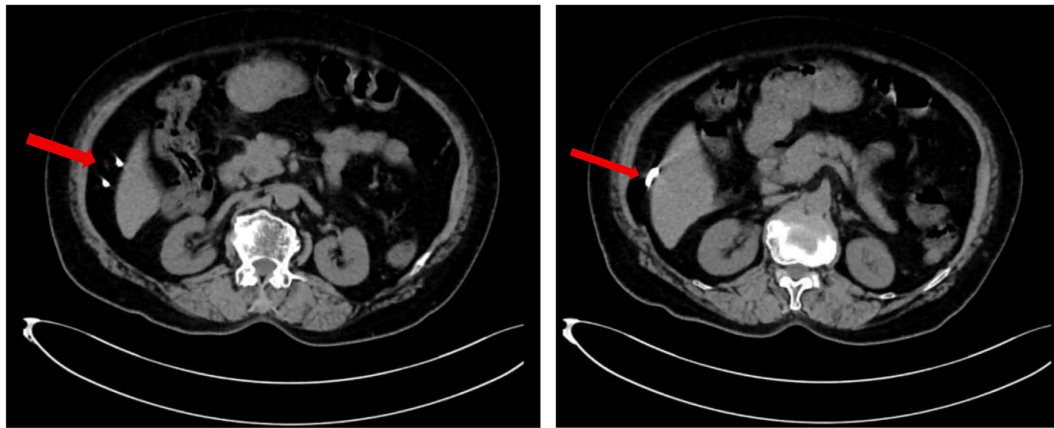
CT examination, horizontal section, high density shadow on the right liver surface is the IUD
